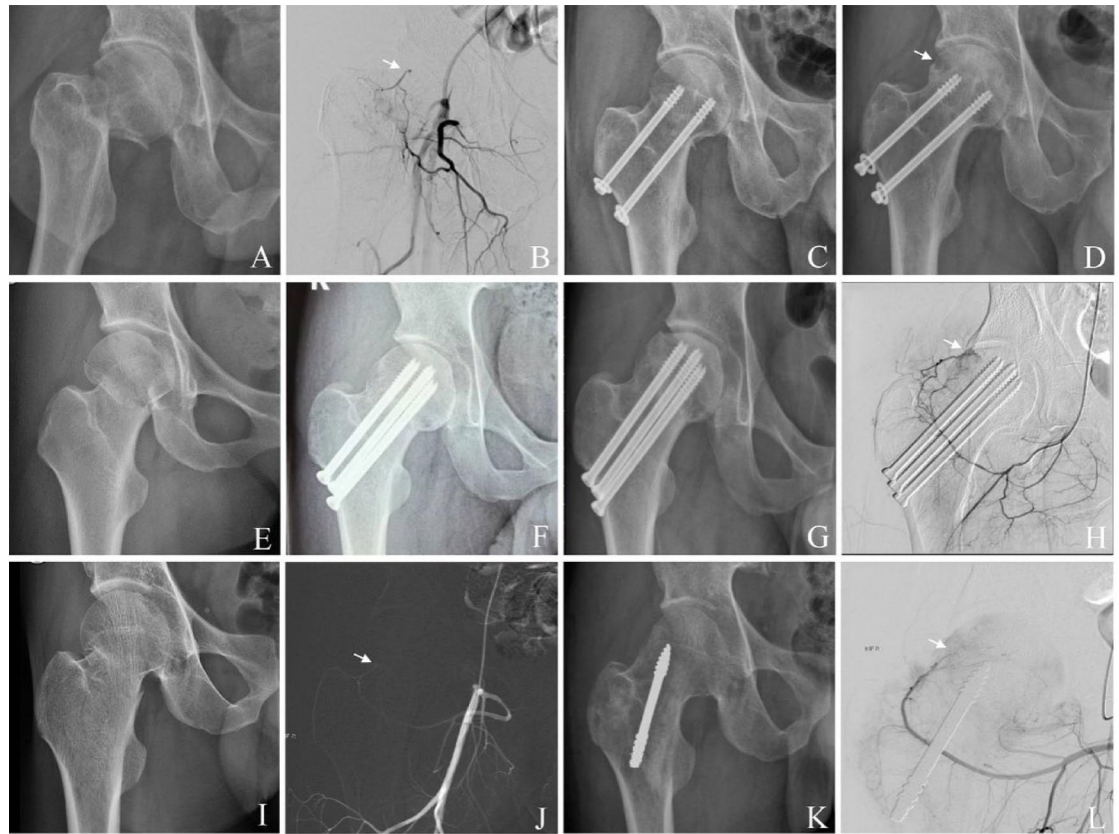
Case 1. (A) A patient with a Garden III type femoral neck fracture. (B) Preoperative DSA showed thickening and interruption of the superior supporting artery supply entering the femoral head. (C) The fracture was fixed with two cannulated screws. (D) At the 6-month postoperative X-ray examination, ischemic necrosis changes were observed in the upper outer portion of the femoral head. Case 2. (E–F) A patient with a Garden II type femoral neck fracture, fixed with three cannulated screws. (G) At 7 months postoperative, X-ray revealed ischemic necrosis and collapse in the weight-bearing area of the femoral head. (H) DSA indicated that the superior supporting artery supply did not extend to the bone area within the screw implantation zone. Case 3. (I) A patient with a Garden I type femoral neck fracture. (J) Preoperative DSA revealed disruption of the superior supporting artery supply at the head-neck junction. (K) The fracture was fixed with a single porous tantalum metal screw, ensuring the distal end did not surpass the epiphyseal line. (L) At 26 months postoperative follow-up, good fracture healing was observed, and DSA demonstrated that the superior supporting artery supply entered the femoral head through the epiphyseal line.
